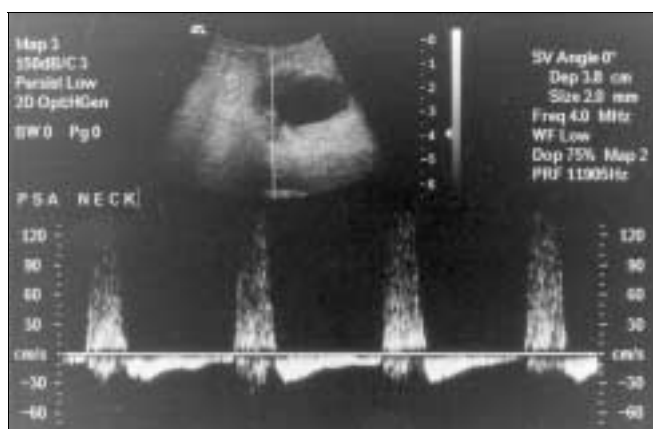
Doppler ultrasound of a right common femoral artery pseudoaneurysm with maximal diameter of 4.2 cm. A typical “to-and-fro” waveform in the neck of the pseudoaneurysm is demonstrated.
